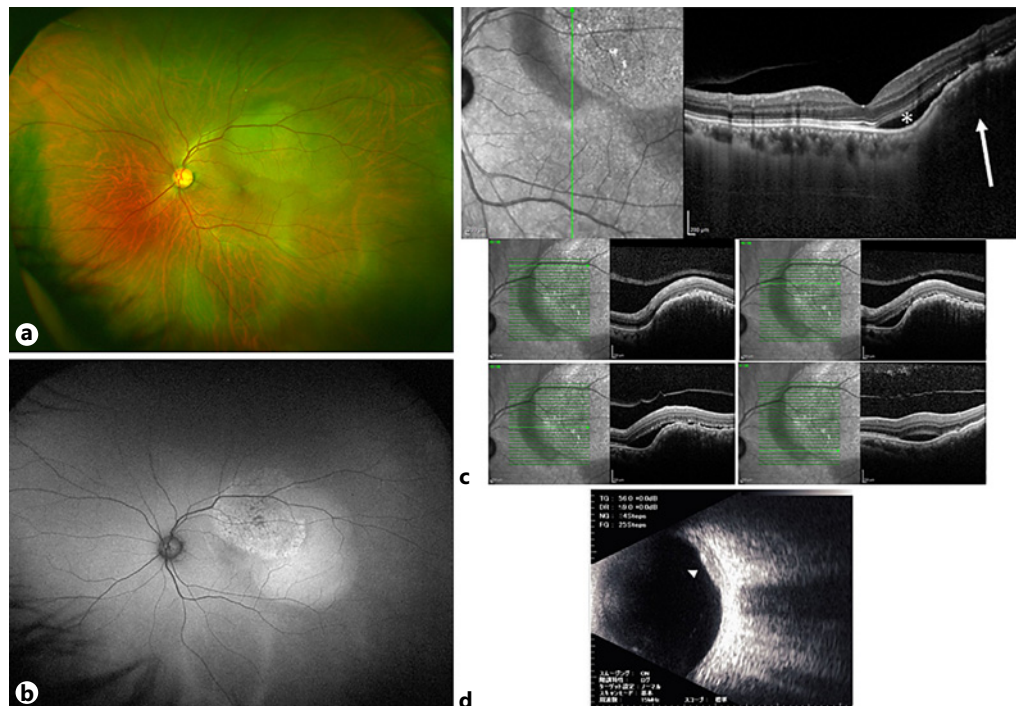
a Widefield fundus photography showed a yellow-white elevated lesion with exudative retinal detachment around the superior vessel in the left eye. b Fundus autofluorescence showed granular and partially hypofluorescent at the protuberant lesion area and hyperfluorescent at the area of exudative retinal detachment. c Optical coherence tomography showed a choroidal mass lesion with a mildly irregular anterior surface (arrow) and subretinal fluid (*). d B-mode ultrasonography revealed a flattened, elevated lesion with medium-to-high reflectivity (arrowhead).
